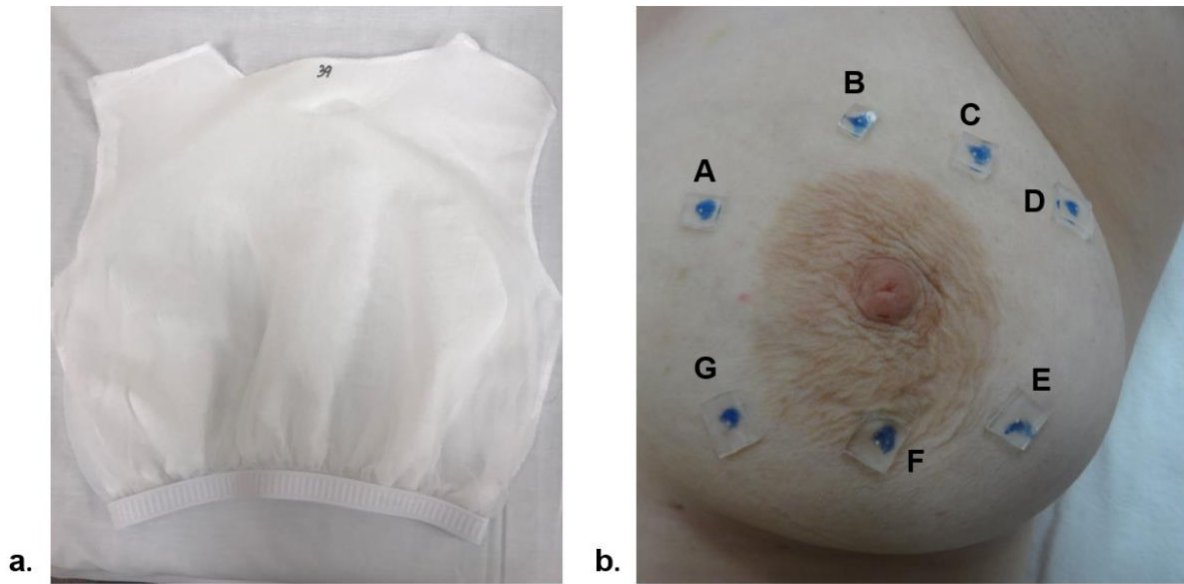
(a) Ultrasound camisole for ABUS imaging (b) External fiducial marker locations (denoted by A-G) shown for marker placements on the left breast
